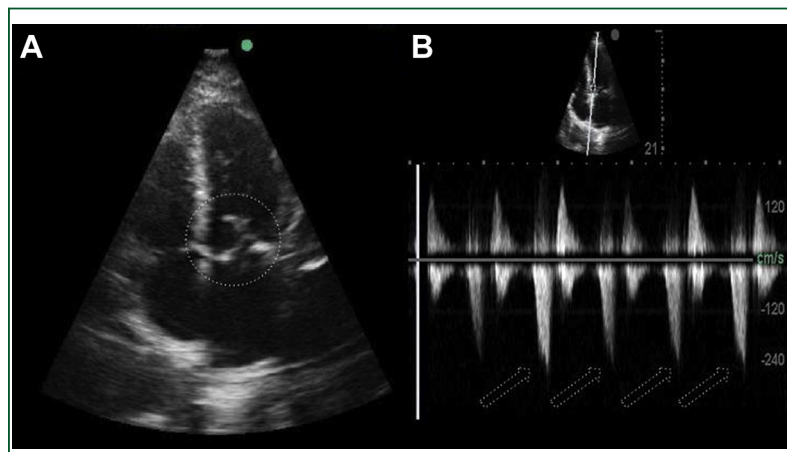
A point-of-care echo demonstrating features of systolic anterior motion due to profound hypovolemia in a burn patient. (A) The anterior mitral valve leaflet is seen to be nearly abutting the septum during systole. (B) The late peaking CW Doppler envelopes during systole (arrows) as obtained from the left ventricular outflow tract are pathognomonic for dynamic obstruction.
